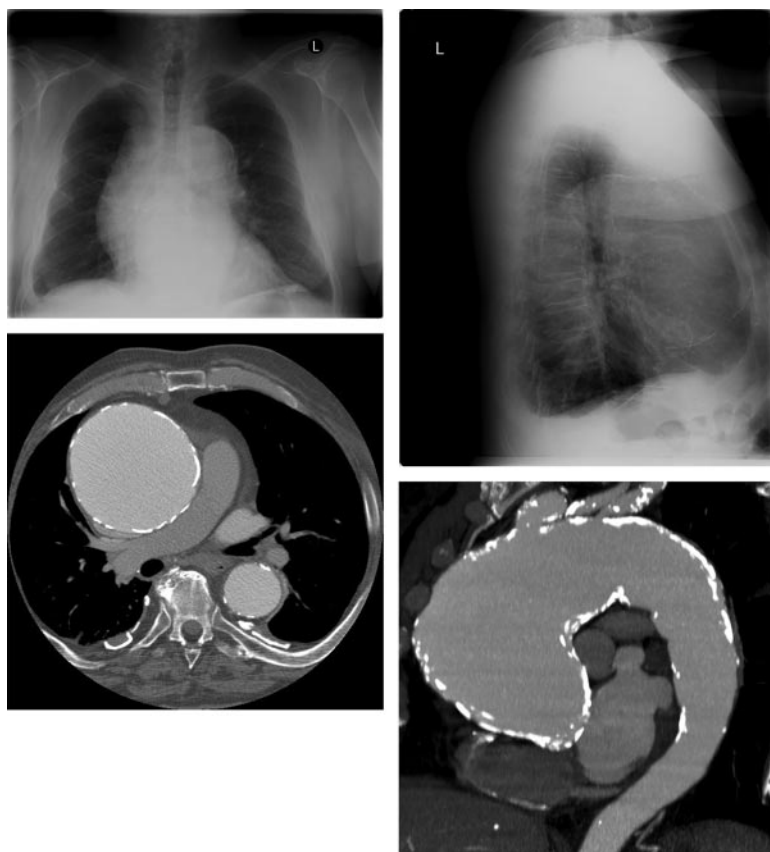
Porcelain aorta. Top left and right, PA and lateral chest x-ray show an anterior mediastinal mass with curvilinear calcifications most likely representing the wall of an ascending aortic aneurysm. Bottom left, CT scan slice at the level of the right pulmonary artery confirms a 10-cm aneurysm of the ascending aorta with dense mural calcifications. Bottom right, A maximum intensity projection in the oblique sagittal plane better demonstrates the fusiform aneurysm beginning at the sinotubular ridge and extending into the aortic arch. Dense mural calcification extends into the proximal descending aorta. CT indicates computed tomographic imaging; and PA, posteroanterior.
